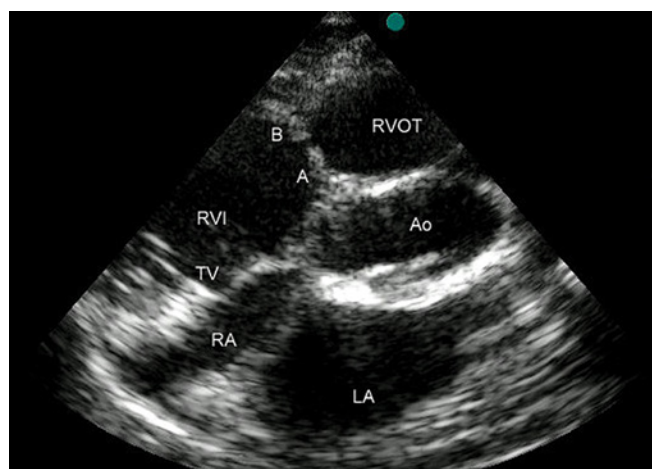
Modified high vascular short-axis view, oriented more sagittally than usual. A fibromuscular diaphragm formed by the above described structures, dividing the right ventricle into a high-pressure inflow chamber (RVI) and a low-pressure outflow chamber (RVOT), is visible. The flow through the diaphragm dividing the RV is visualized using color Doppler. Only a 3–4 mm communication between the two chambers of the right ventricle is visible. Ao – Aortic valve, LA Left Atrium, RA Right Atrium, TV – Tricuspid Valve: A. moderator band; B. Hypertrophied band on the anterior wall of RV
